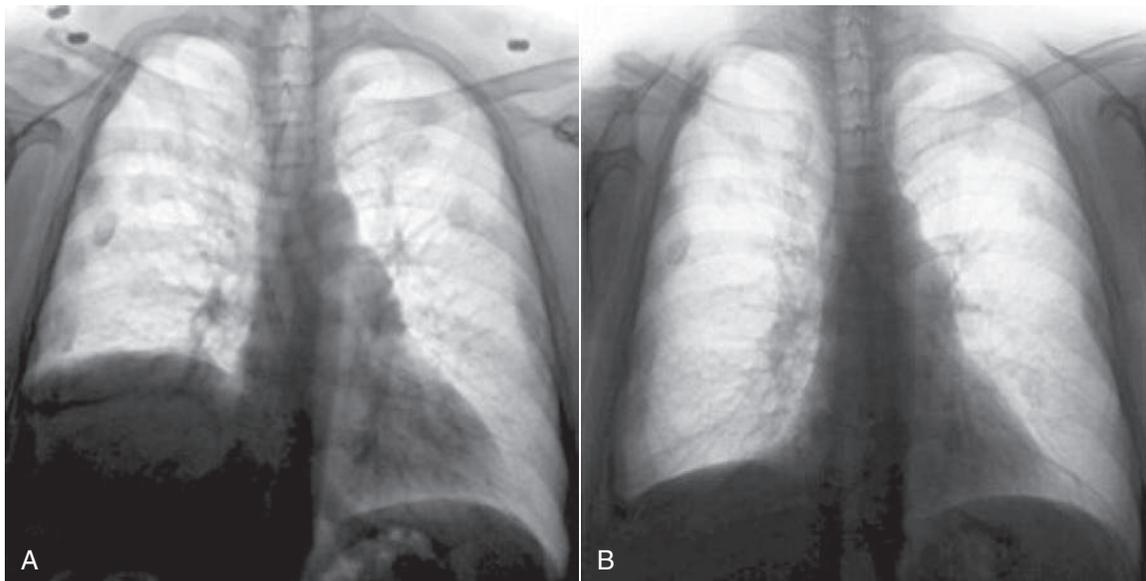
A, Chest radiograph showing elevation of a right hemidiaphragm. B, Chest radiograph in the same patient 1 year after laparoscopic diaphragm plication. (From Groth SS, Andrade RS: Diaphragm plication for eventration or paralysis: a review of the literature. *Ann Thorac Surg* 89:S2146–S2150, 2010.)
